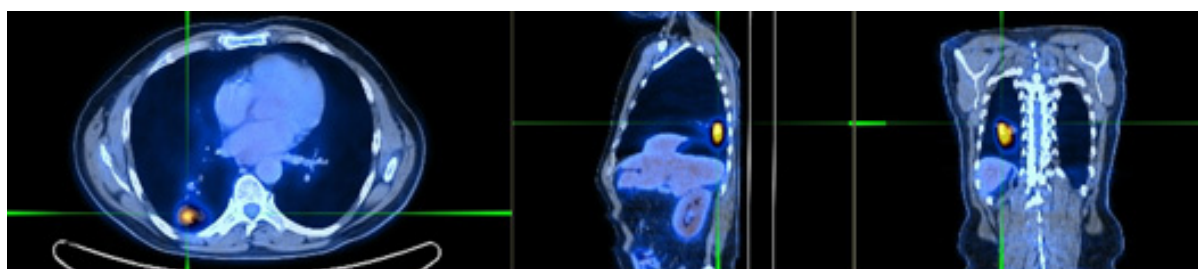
The accuracy offered by PET-CT in pinpointing a lung tumour.
